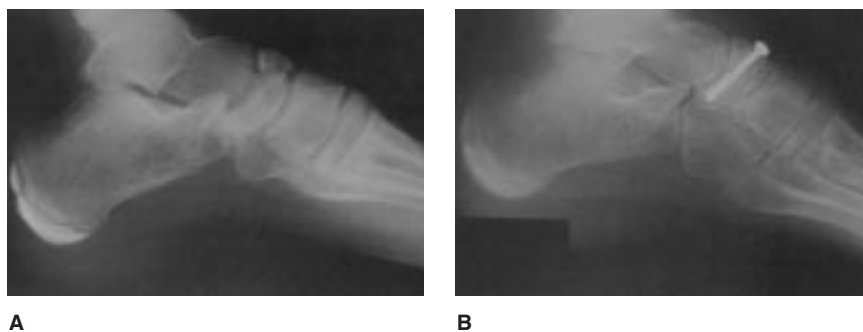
Preoperative (A) and postoperative (B) radiographs of a foot with a type 1 injury treated with ORIF. (Reproduced with permission from Sangeorzan BJ, Benirschke SK, Mosca V, Mayo KA, Hansen ST Jr: Displaced intra-articular fractures of the tarsal navicular. *J Bone Joint Surg Am* 1989;71:1504-1510.)
